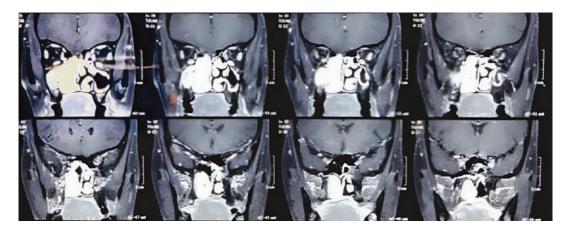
MRI scan shows a lesion involving the right maxilla and right-sided nasal cavity
